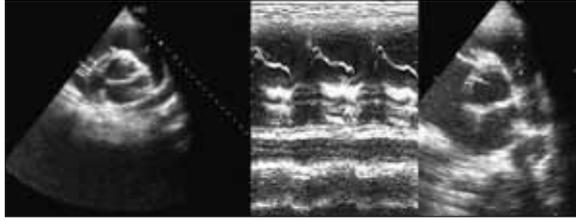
Parasternal short-axis and M-mode transthoracic echocardiographic views of the pulmonary valve prolapse
